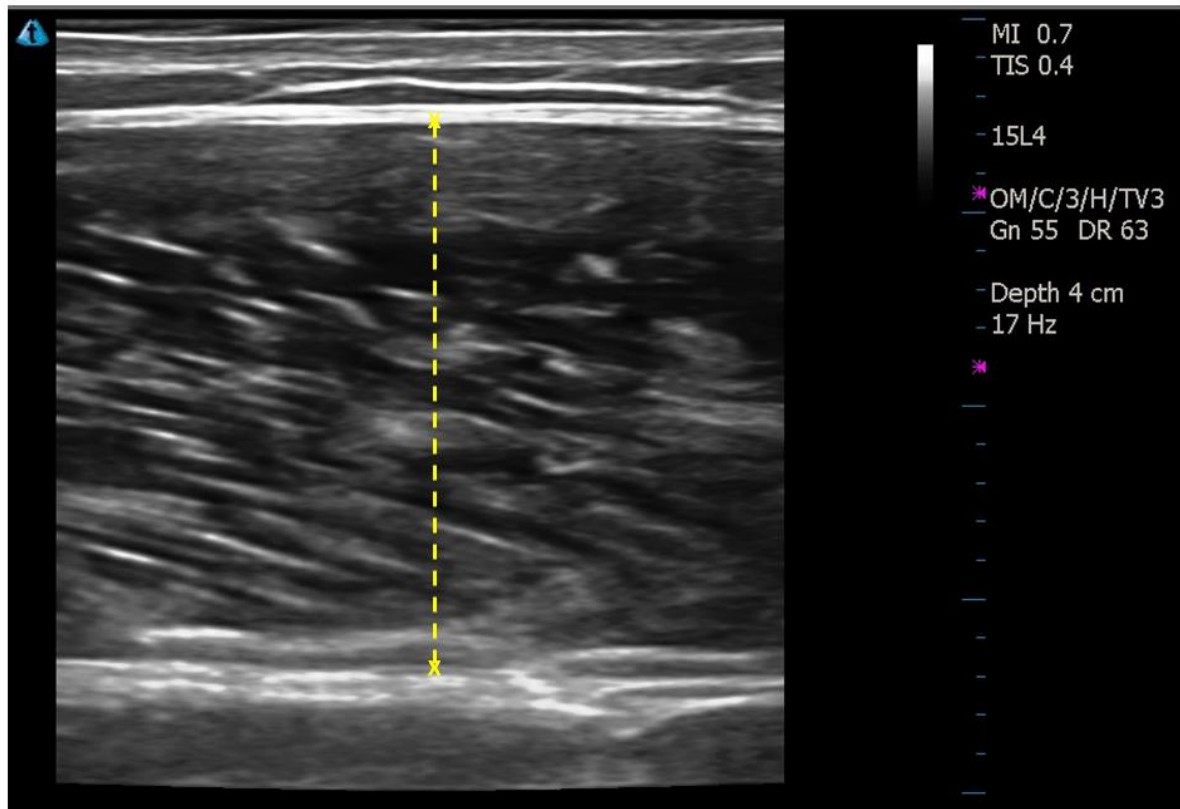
Vastus lateralis* muscle thickness via B-mode ultrasound.
